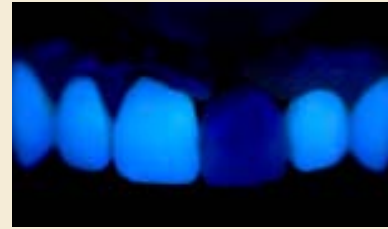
(Left) Periapical radiograph used to verify fit.
